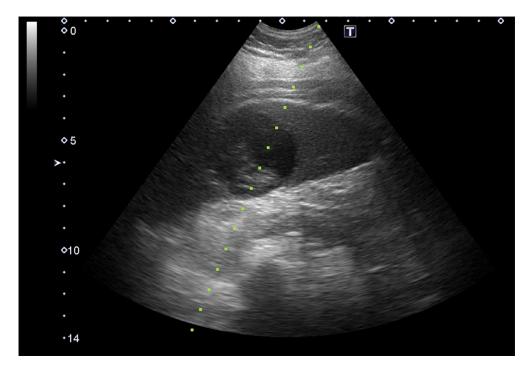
Abdominal ultrasonography at admission. A hypoechoic area with indistinct boundaries, ca. 5 cm in diameter, can be observed in the spleen.
